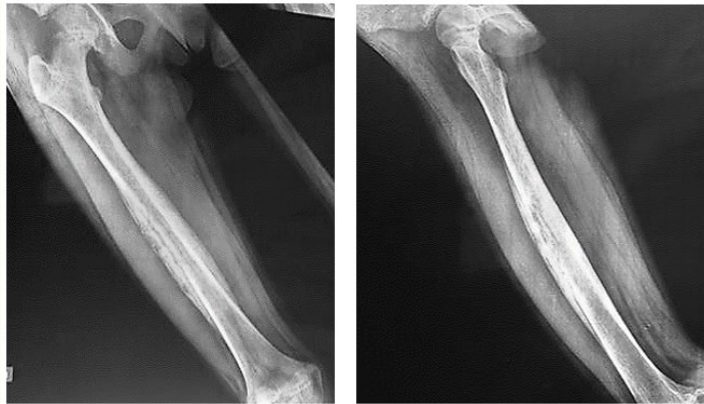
Figure 1: X-ray of the femur showing multilamellar reaction.
